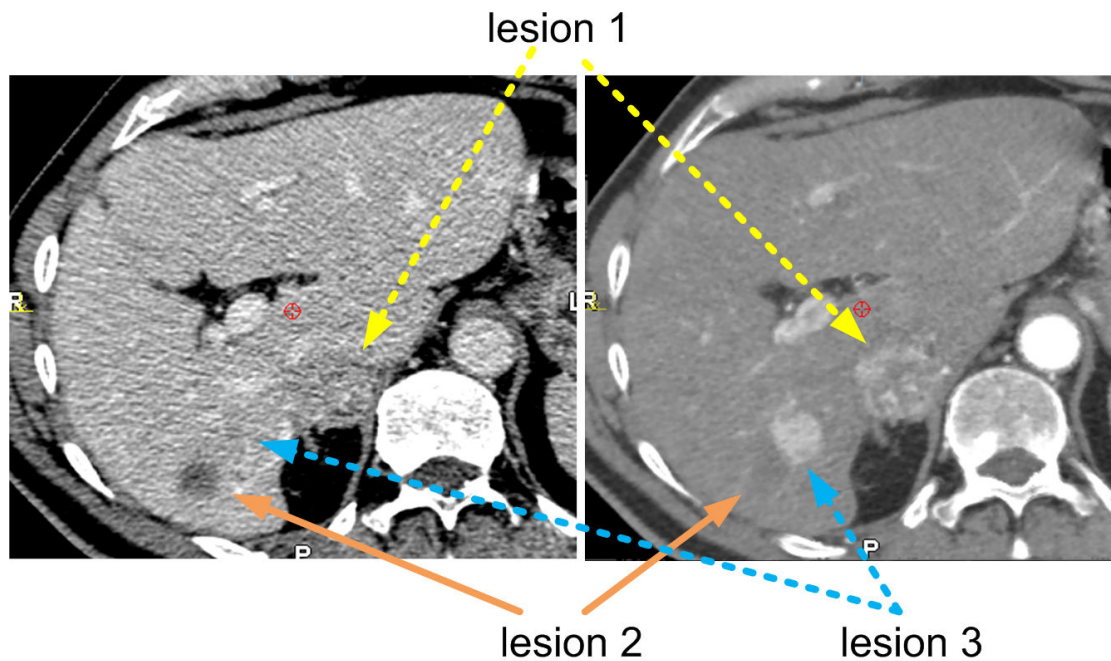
Liver CT scan of the portal venous phase (left) and the arterial phase (right). 3 different lesions are shown in both images. Lesion 1 and lesion 3 are visible only in the arterial phase while lesion 2 is only visible in the portal venous phase.
